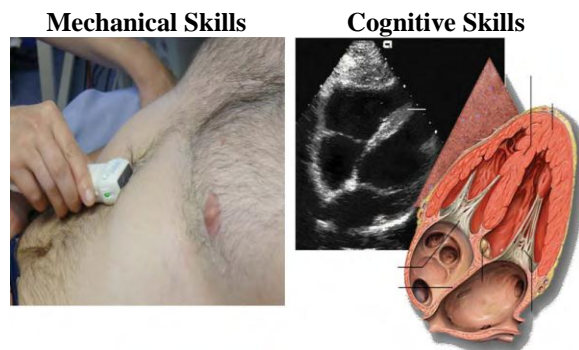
Bedside Ultrasonography Skills
